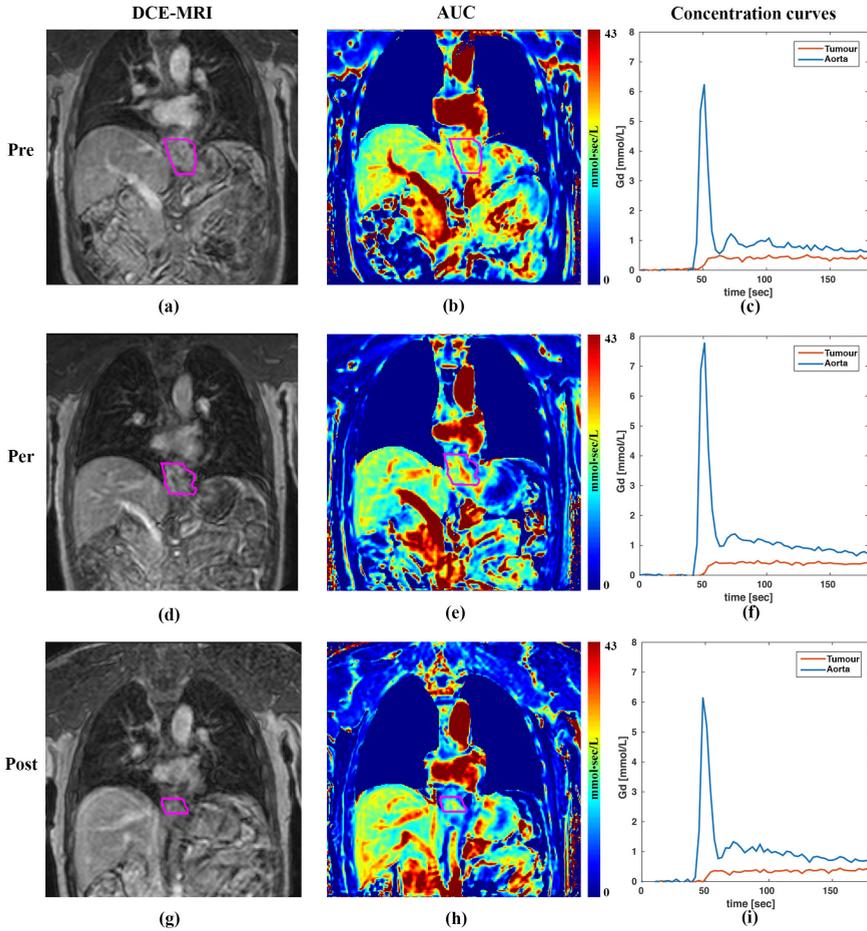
(a) Coronal view of DCE-MRI (after contrast agent injection) of a pathologic complete responder before treatment (pre) with the tumor contour in pink. (b) Corresponding AUC map (60 seconds after contrast inflow). (d,e) Corresponding images after two weeks of nCRT (i.e. during treatment), showing a reduction in tumor AUC values during treatment. (g,h) Corresponding images after treatment, showing further reduction in AUC values along with a decrease in volume. (c,f,i) Corresponding concentration time curves measured in a slice in the aorta and tumor, for pre-, per- and post-treatment scans, respectively.
